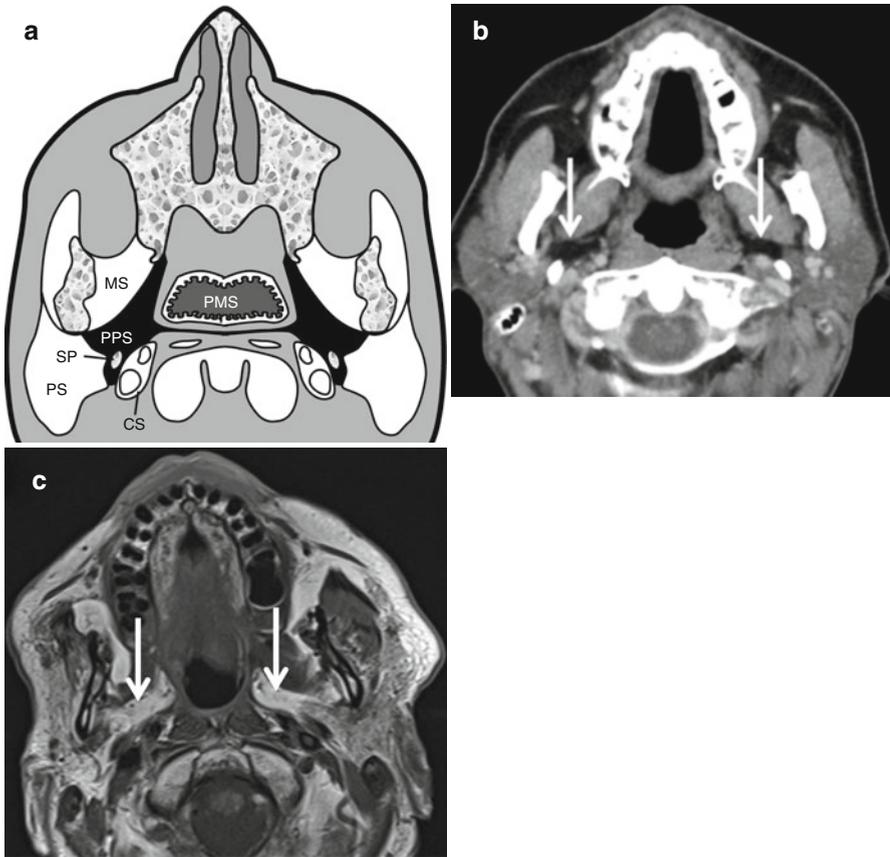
Neck spaces. Axial graphic (a), CT (b), and T1-weighted MR (c) images show the normal anatomy of the parapharyngeal space (PPS). This space predominantly contains fat and can be easily identified (*arrows* in b and c) on both CT (hypodense on CT) and MR (bright on T1-weighted sequences) images. The central location of this space is the reason for its displacement in lesions arising from the adjacent masticator space (MS), parotid space (PS), carotid space (CS), and the pharyngeal mucosal space (PMS). The styloid process (SP) is along the posterior aspect of the parapharyngeal space and can be completely surrounded by adjacent fat
